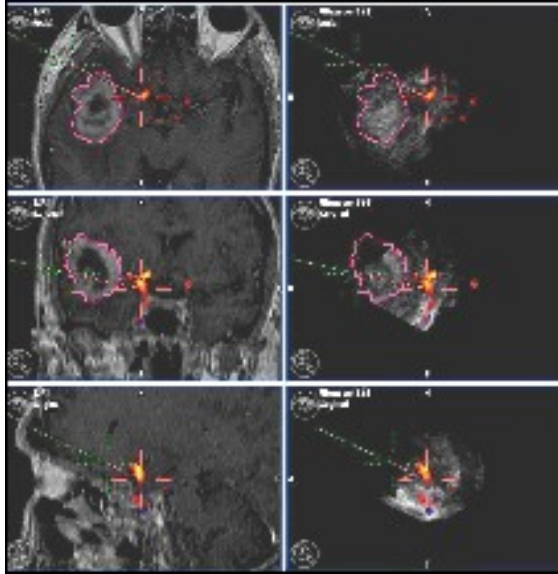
The preoperatively outlined tumor (malignant glioma left temporal lobe) is displayed by intraoperatively ultrasound 3D reconstruction in the familiar planes and though 3D acquisition of the Doppler mode major vessels are landmarked and superimposed (coloured) on both image data sets.
